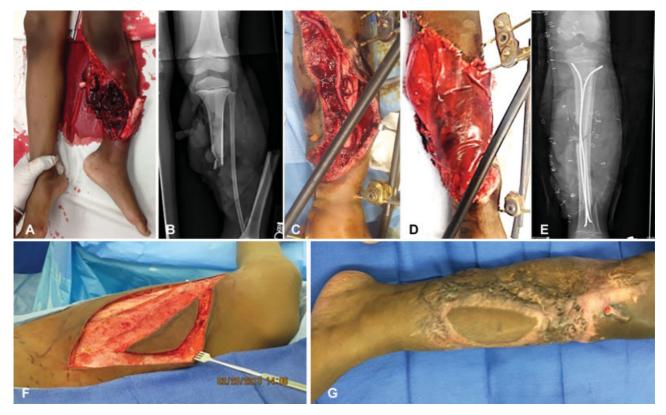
(A) 8-year-old child presenting with a Gustilo IIIC injury (open tibial fracture and posterior tibial artery avulsion) following motor vehicle accident. (B) Radiograph demonstrating mid-shaft fracture of the tibia. (C) Fracture was stabilized with external fixation and a vascular bypass was performed from proximal to distal posterior tibial artery with reversed saphenous vein. (D) Provisional coverage was achieved for 24 hours with dermal substitute. (E) Conversion to internal fixation. (F) Free latissimus myocutaneous flap reconstruction as well as skin graft was performed on day 3 postinjury as a single procedure by an orthoplastic team to provide adequate soft tissue coverage of the vascular bypass. (G) Patient developed hypertrophic scarring of his skin graft but had a functional extremity at long-term follow-up.
